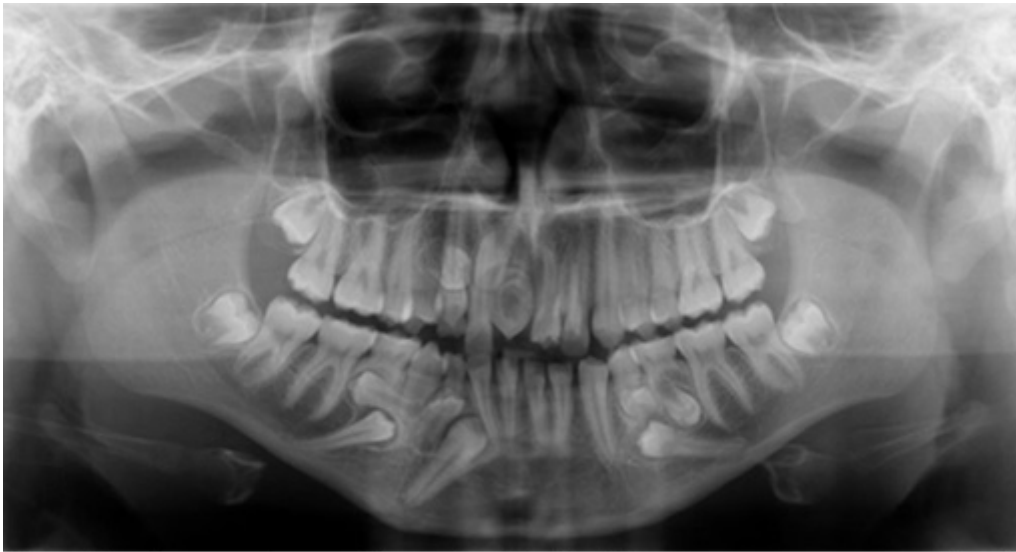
Panoramic radiograph highlighting supernumerary teeth (yellow), both mesiodens included, and impacted permanent teeth (black). The unusual morphology of the mesiodens located to the right side can.
